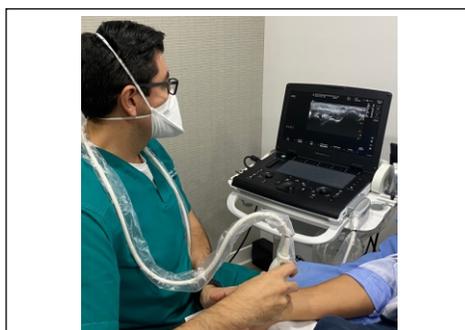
CEO Medical Records. Ultrasound examination of scaphoid fracture under ultrasound vision.
